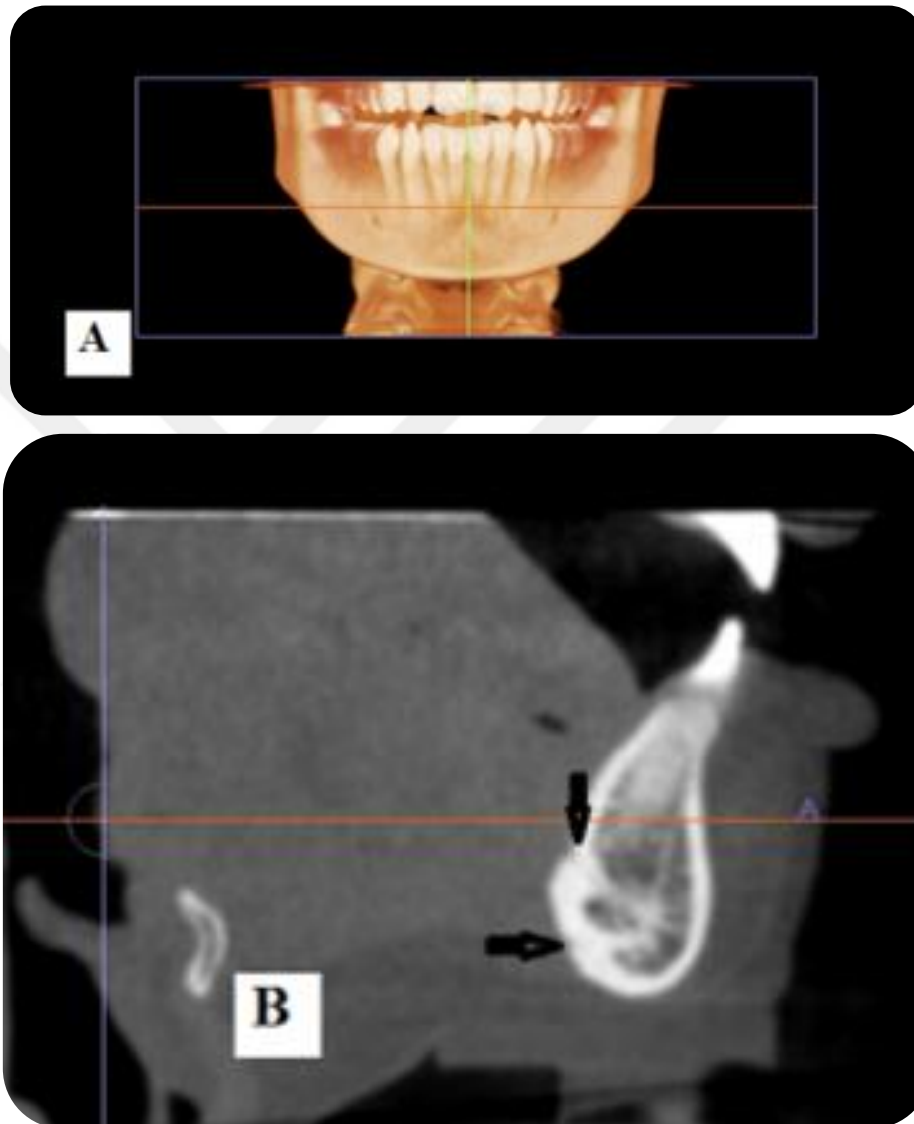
Sections at the midline. A: Volumetric 3-D representation of the mandible showing the level of the sagittal section at the midline. B: the cross- section of the same case at the midline, showing two lingual canals; one above the genial tubercle (radiopaque protrusion), opening in a superior direction (vertical black arrow), and the other canal below the genial tubercle opening in an inferior direction (horizontal black arrow) (Images obtained with i-CAT® Model 17-19; CBCT Imaging Unit: InVivoDental5 Version 5.2 Anatomage, software): Dentomaxillofacial Radiology Department; Faculty of Dentistry- University of Yeditepe.
